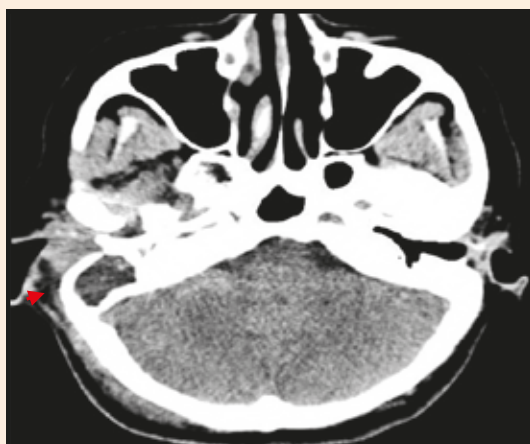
A mastoid CT scan with IV contrast. An axial cut shows no evidence of an intracranial collection. Note the subcutaneous swelling (diffuse enhancement) in the right post-auricular area without obvious collection.
